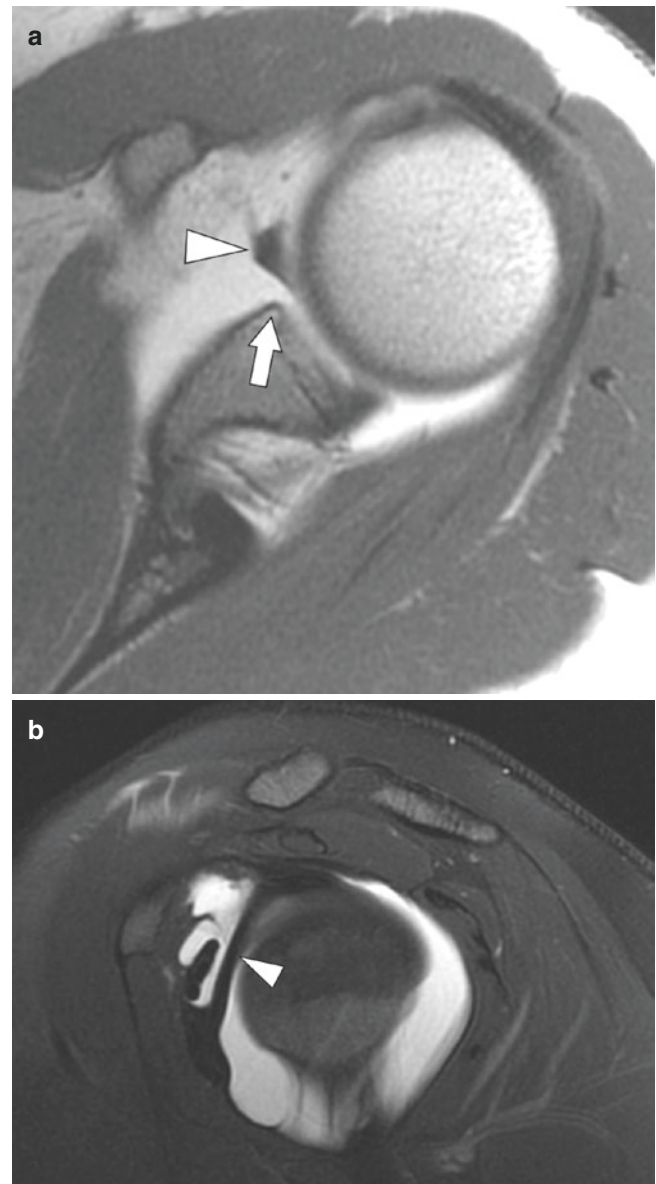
Buford complex normal labral variant (a) Axial T1-weighted and (b) oblique sagittal fat-suppressed T2-weighted images show an absent anterosuperior labrum (arrow) and a thick, cord-like middle glenohumeral ligament (arrowheads), known as a Buford complex
